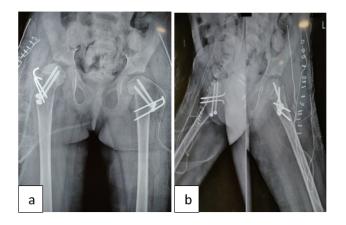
Post-operative x-ray a) AP view b) Lateral view
